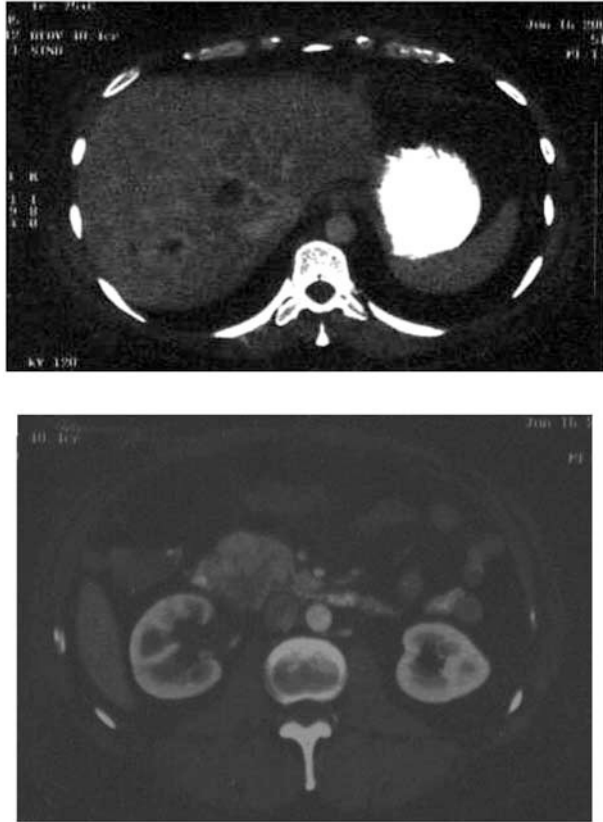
Computed tomography scan from June 2005 shows stable primary metastatic hepatic lesions (top) and stable shrunken primary pancreatic lesions (bottom) as compared to October 2002.
